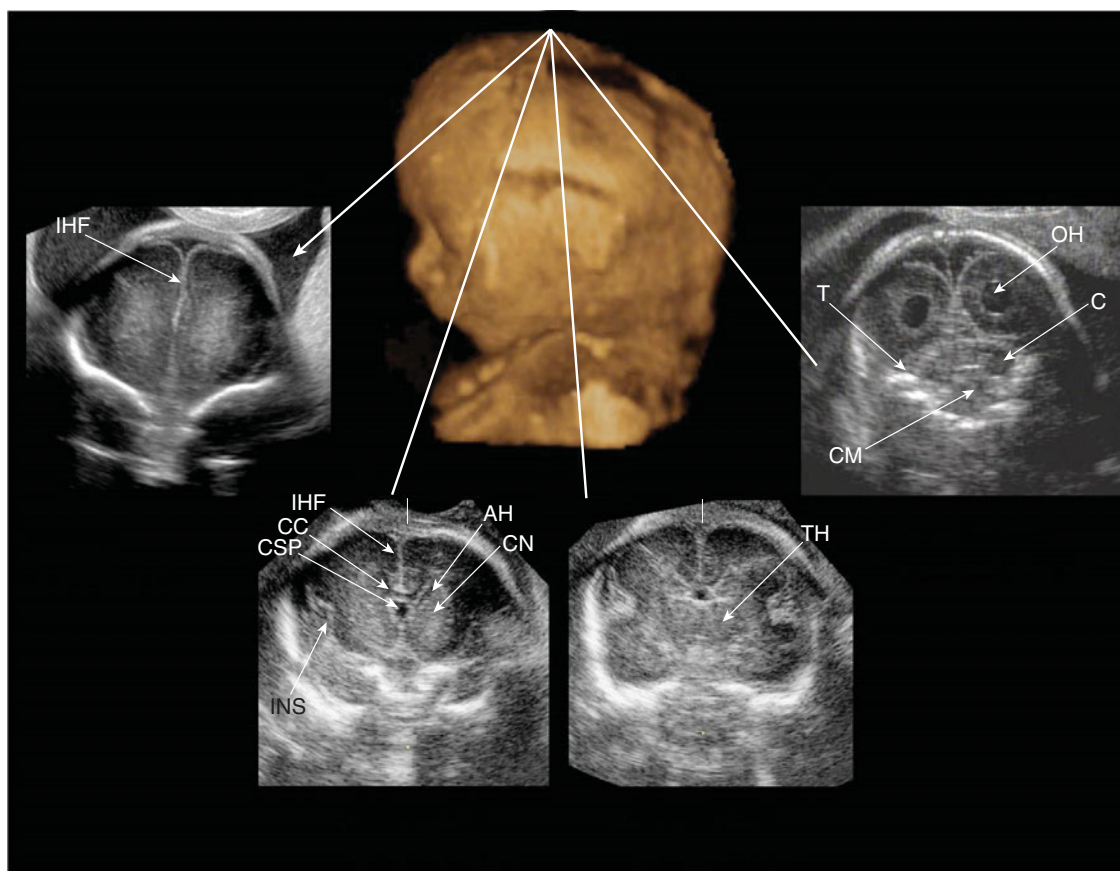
The targeted or more detailed fetal neurosonogram contains other planes and sections; the coronal planes are displayed in this figure.
